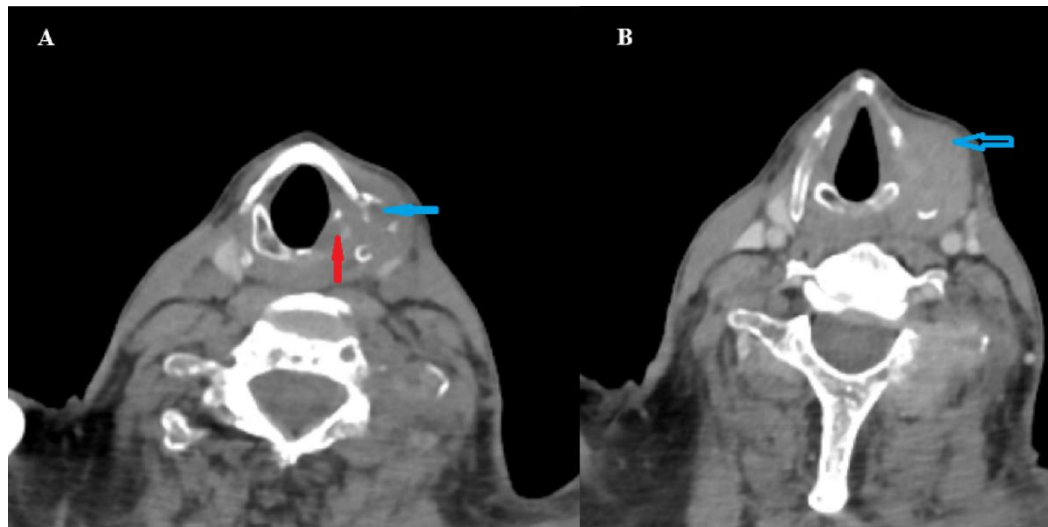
Axial CT scans of the neck in soft-tissue window mode showing destructive involvement of the left laryngeal cartilage due to multiple myeloma
